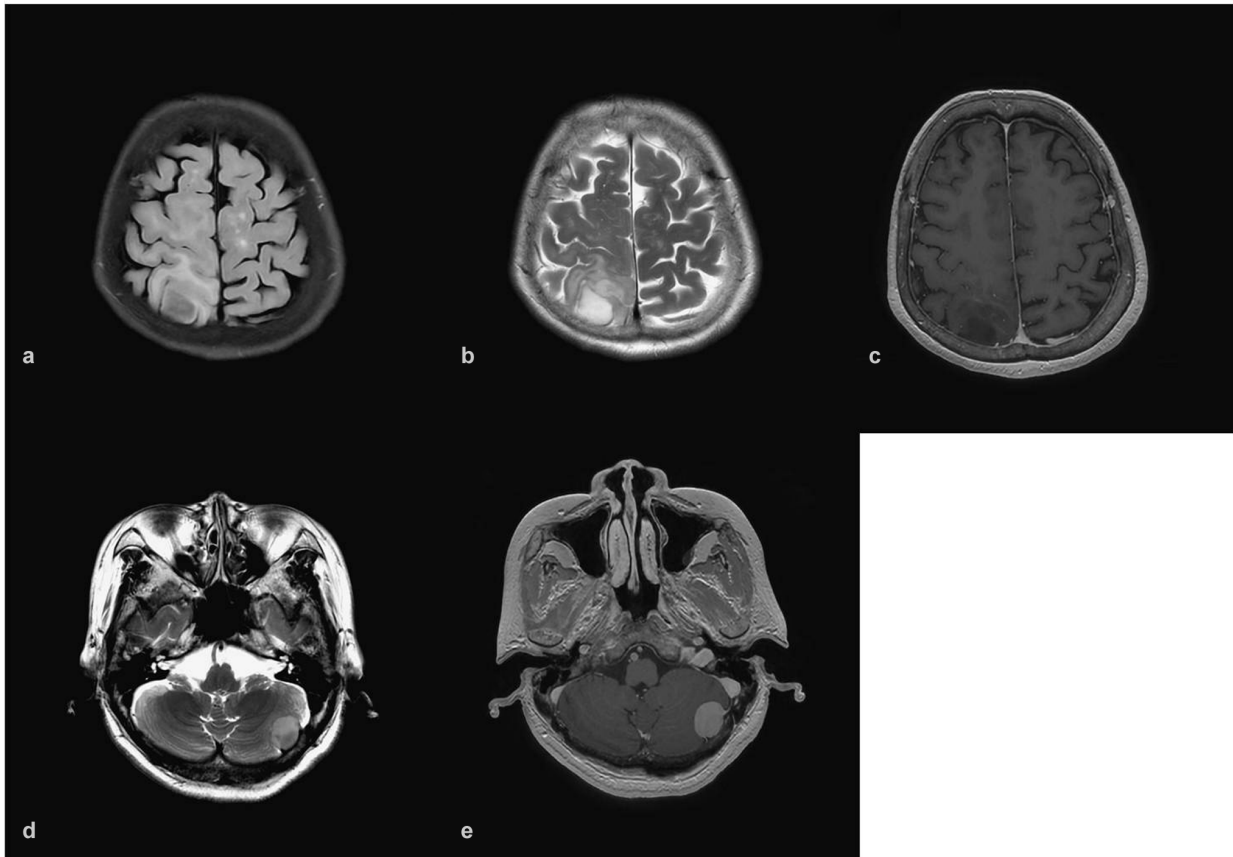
Preoperative brain magnetic resonance imaging (MRI). Axial T2 fluid-attenuated inversion recovery (FLAIR) (a) and axial T2-weighted image (T2WI) (b) showing an infiltrative lesion with high signal intensity involving the right superior parietal lobule. Axial T1-weighted image (T1WI) post gadolinium injection (c) showing subtle enhancement. Axial T2WI (d) demonstrating an iso-to-high signal intensity lesion in the left cerebellar region and axial T1WI post gadolinium injection (e) revealing well enhancement.
